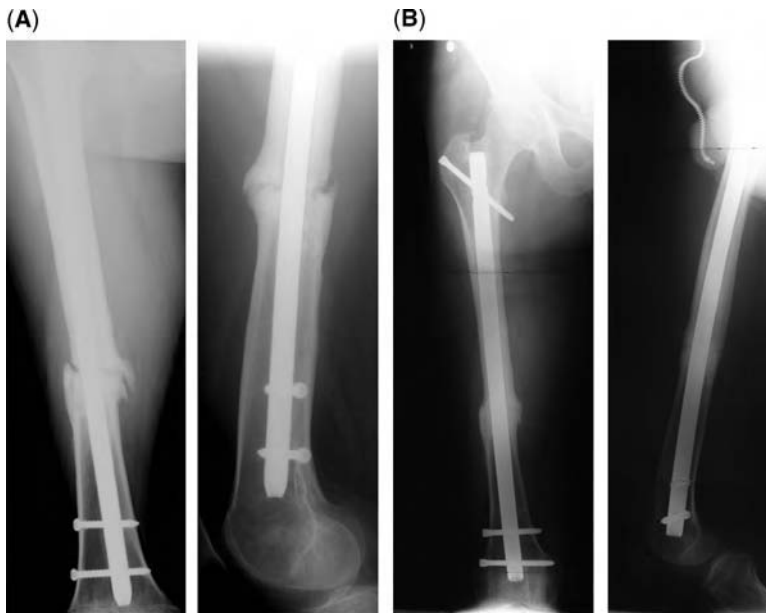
(A) Presenting anteroposterior (AP) and lateral radiographs of a 33-year-old man referred in for a diaphyseal nonunion 11 months following intramedullary nail fixation. (B) Follow-up AP and lateral radiographs seven months following exchange nailing show solid bony union.
